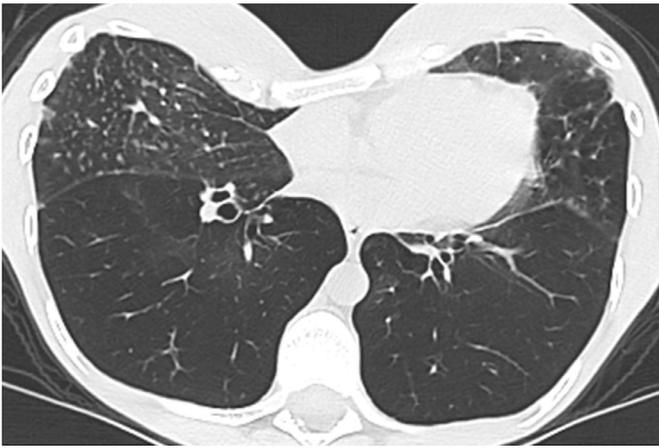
Diffuse alveolar hemorrhage 14 days after HSCT. CT shows bilateral ground-glass opacities, worse on the right. Bronchoalveolar lavage revealed hemorrhagic fluid and hemosiderin-laden macrophages were seen on cytologic analysis.
